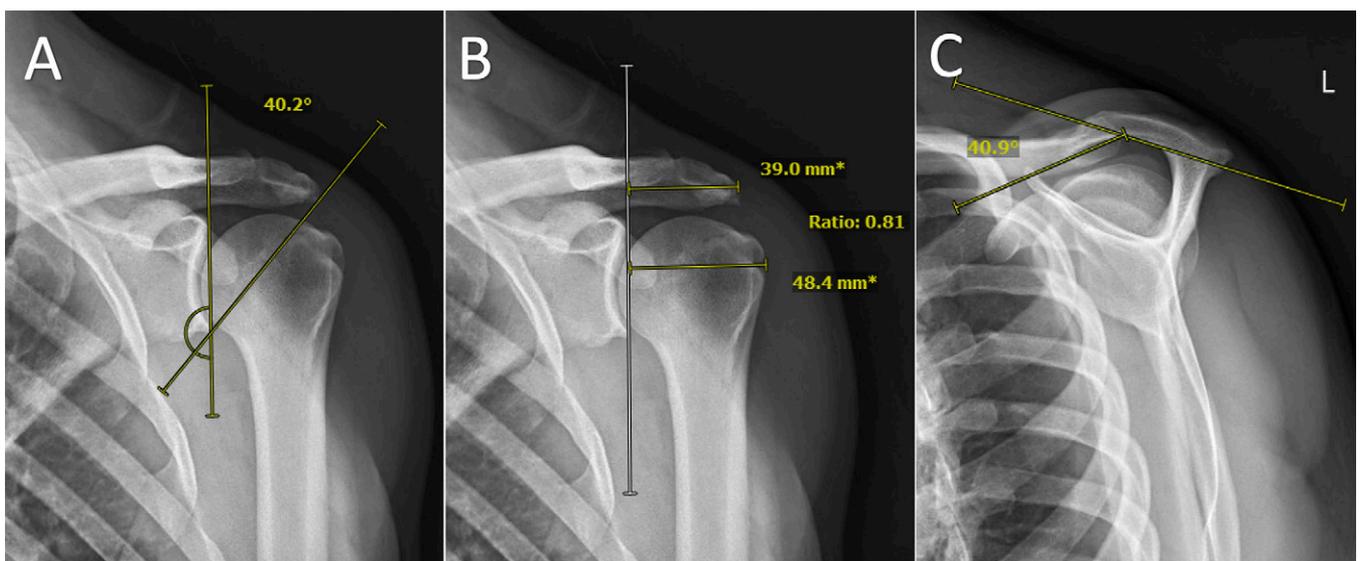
Radiographic predictors of partial-thickness rotator cuff tear incidence and retear risk after repair. Fig. 1-A Critical shoulder angle. Fig. 1-B Acromial index. Fig. 1-C Acromial slope.
